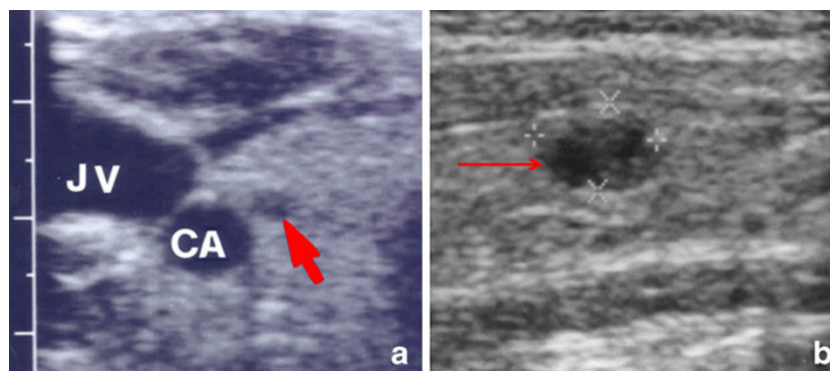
a Sonography image demonstrating a small round hypoechoic nodule at the right lobe of the thyroid gland of a patient with CNC (red arrow). The lesion corresponds to an adenomatous nodule (CA carotid artery, JV jugular vein). b Sonography image demonstrating an ovoid
